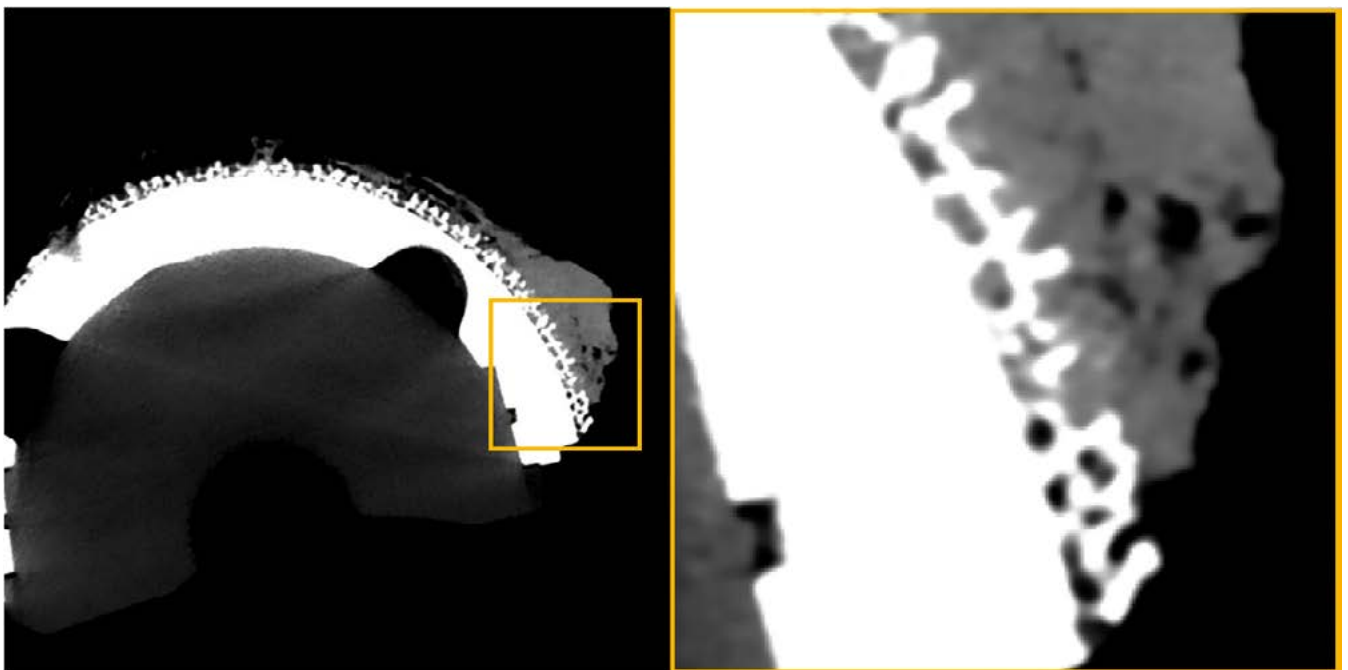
Visualization of the implant-bone interface with PCD-CT. The ingrowth of bone tissue into the porous structure on the implant surface can clearly be seen.
